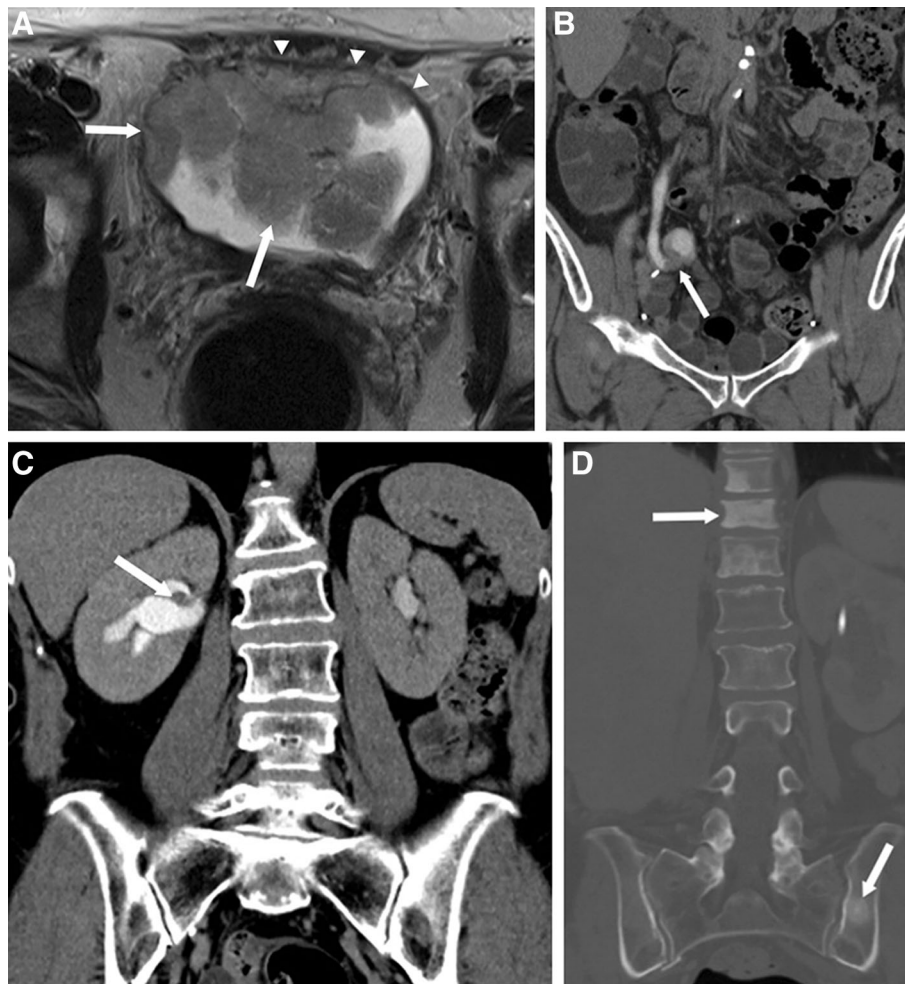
65-year-old woman with history of recurrent, high-grade papillary urothelial cancer (pT1a stage). A Axial T2-weighted MR image shows a large multi-lobular mass originating from the anterior bladder wall, almost completely replacing the bladder cavity (*white arrows A*). The outer contour of the detrusor muscle is intact (*white arrowheads A*). Cystectomy revealed high-grade pT1a disease. B Follow-up coronal CT urogram image in excretory phase obtained
